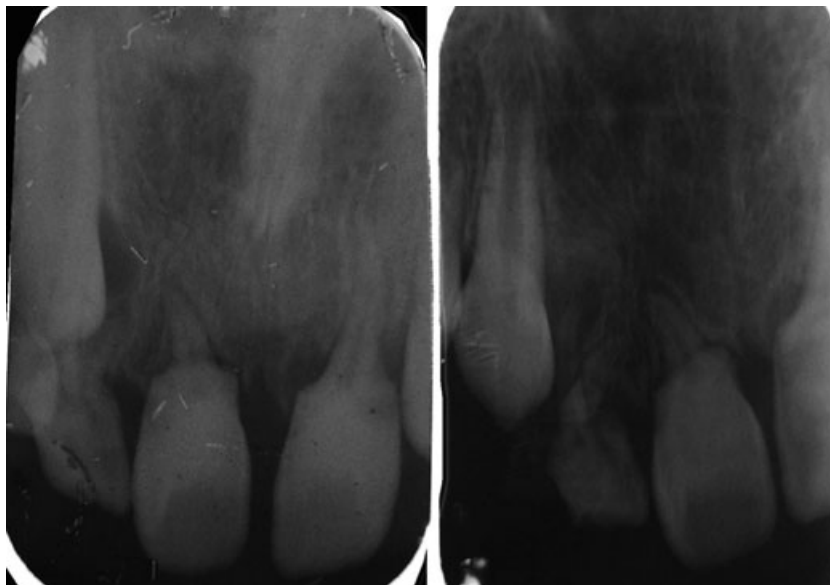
Intra-oral periapical radiographs showing thin and curved root in 11, 21 and 12 along with root duplication in 12.
